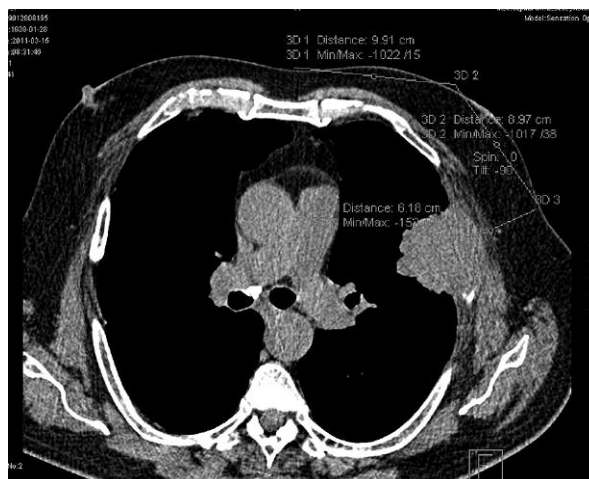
Computed tomography imaging scan – establishing the distance, place and depth of the puncture
